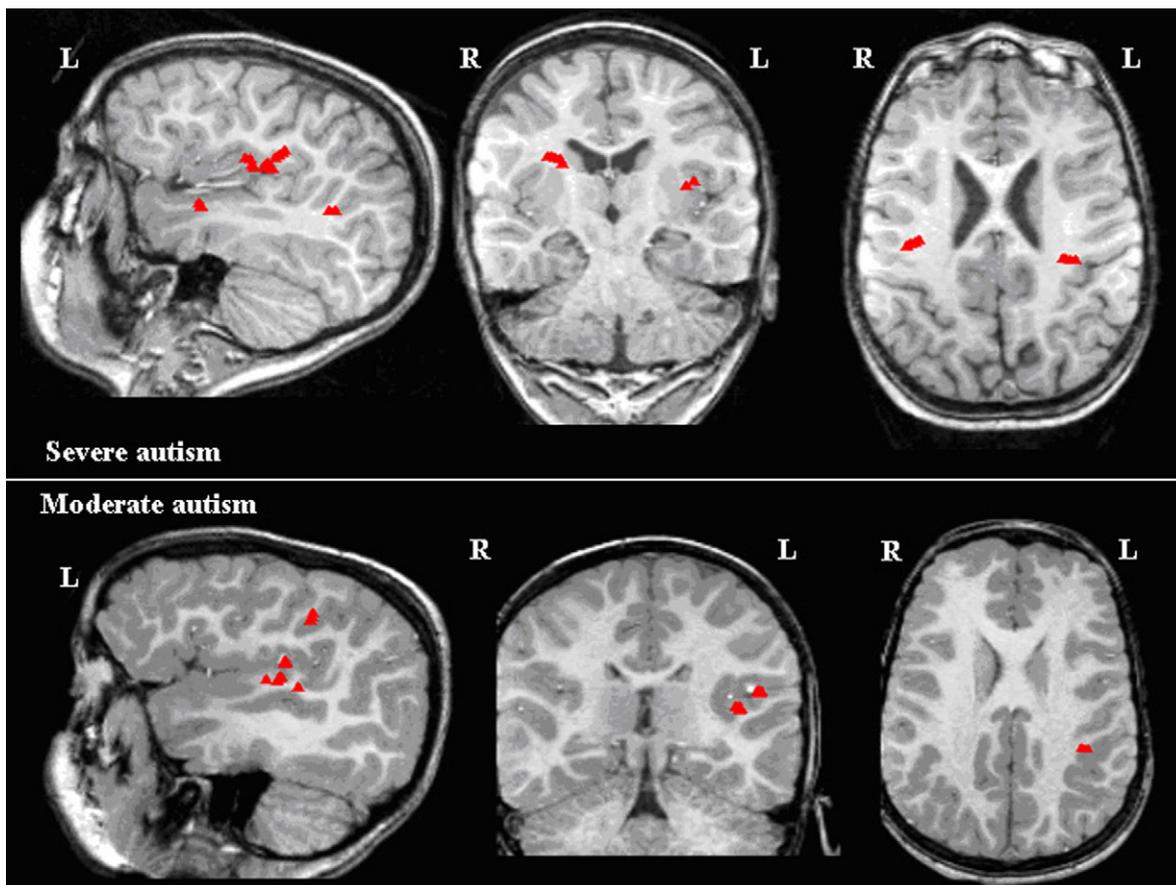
Representation of MEG dipoles on MRI scans in a case of severe autism compared with moderate autism (triangles: paroxysmal rhythmic activity dipoles).
